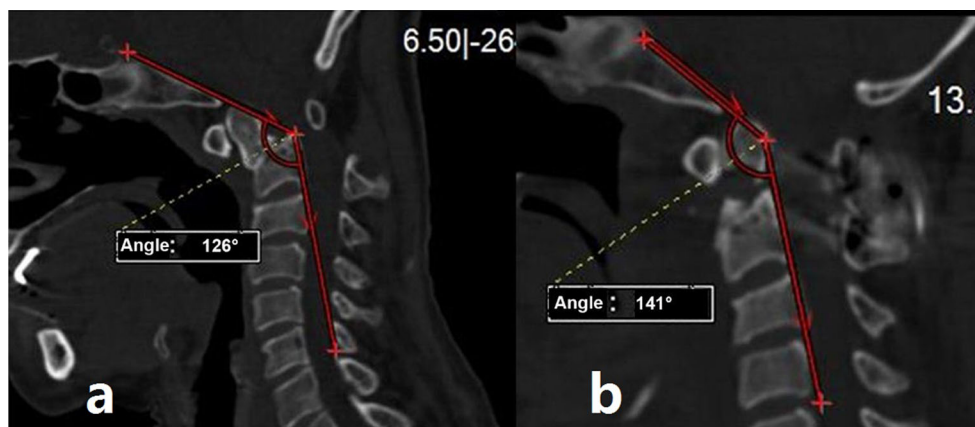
CT reexamination showed that the atlantoepisthophic slope angle increased from 126° to 141° (a, b) and the ventral spinal cord was completely decompressed (b)
